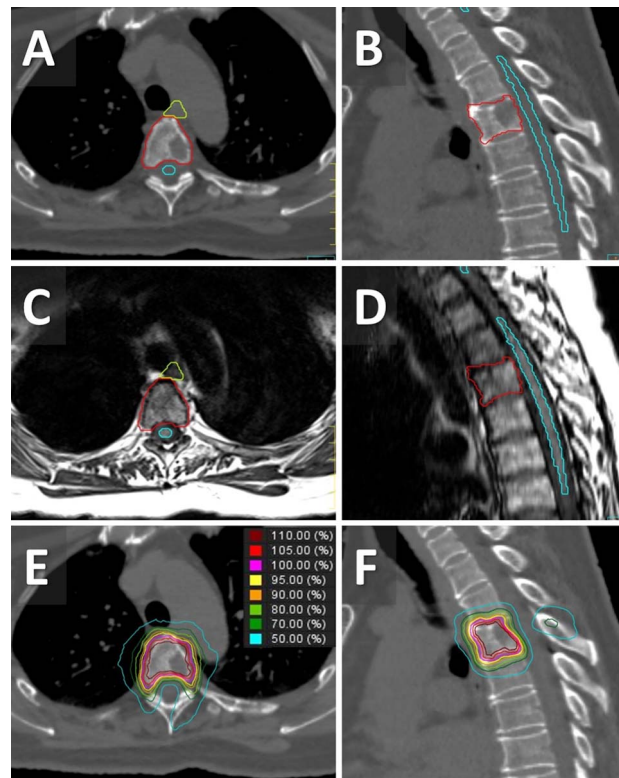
Images obtained from a 61-year-old woman with metastasis to the fourth thoracic vertebra from lung cancer. (A, B) Axial and sagittal computed tomography (CT) images with contouring for planning stereotactic body radiotherapy (SBRT). (C, D) Axial and sagittal T1-weighted magnetic resonance (MR) images with contouring for planning SBRT. (E, F) Axial and sagittal CT images with dose distributions of SBRT.
